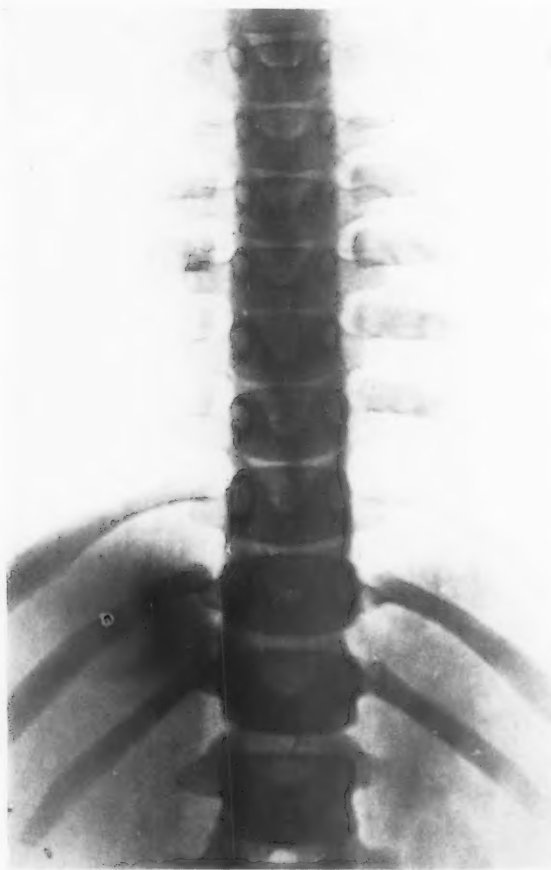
X-ray of vertebrae (November 23, 1936). Bodies of the vertebrae show increased density (eburnization).
